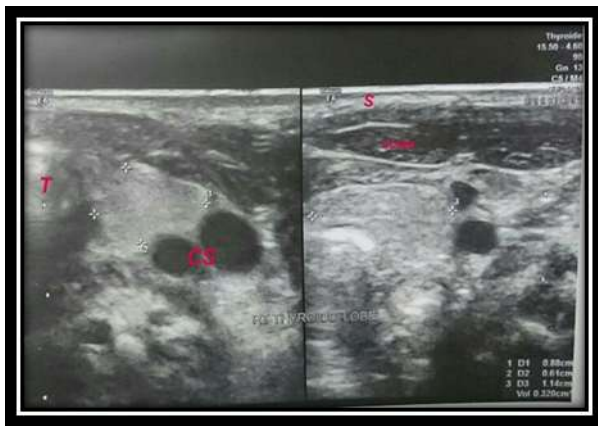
Ultrasound of right lobe neonate thyroid gland, CS carotid sheath, SCMM sternocleidomastoid muscle, T trachea all these structures surround the gland.
